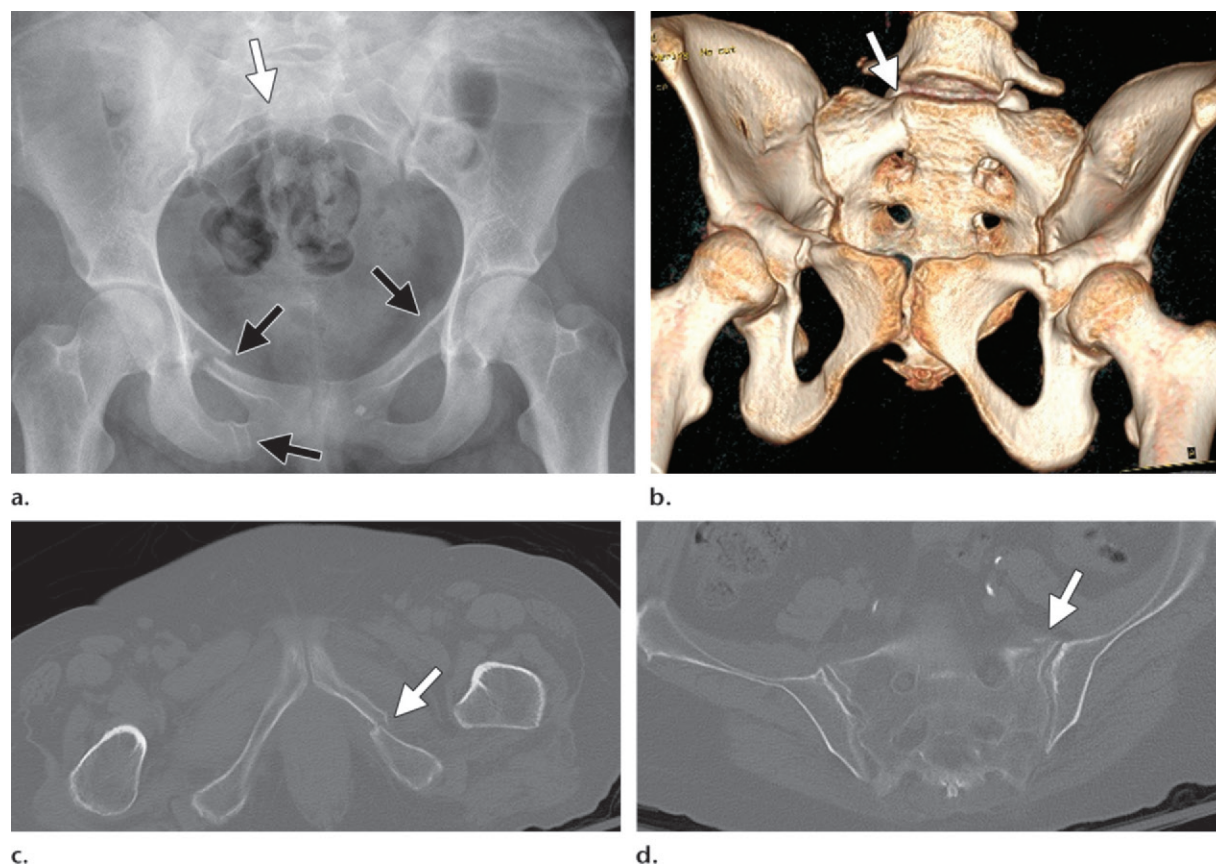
Lateral compression type 1 injury in two patients. (a) AP radiograph of the pelvis obtained in a 16-year-old patient who was a backseat passenger in a motor vehicle accident shows bilateral superior and right-sided inferior pubic rami fractures (black arrows) and a subtle disruption of a right sacral arcuate line (white arrow). (b) Three-dimensional volume-rendered CT image obtained in the same patient as in a shows a zone II fracture disrupting the neuroforamen (arrow), with no widening of the SI joint. (c) Axial CT image obtained in a 77-year-old woman who presented with left hip pain after falling on her left side while exiting her car shows an overlapping horizontal inferior pubic ramus fracture (arrow). (d) Axial CT image obtained in the same patient as in c shows a buckle fracture of the left anterior sacrum (arrow) secondary to compression. No SI joint widening is seen. Both patients were conservatively treated because of the stability of the fracture pattern.
